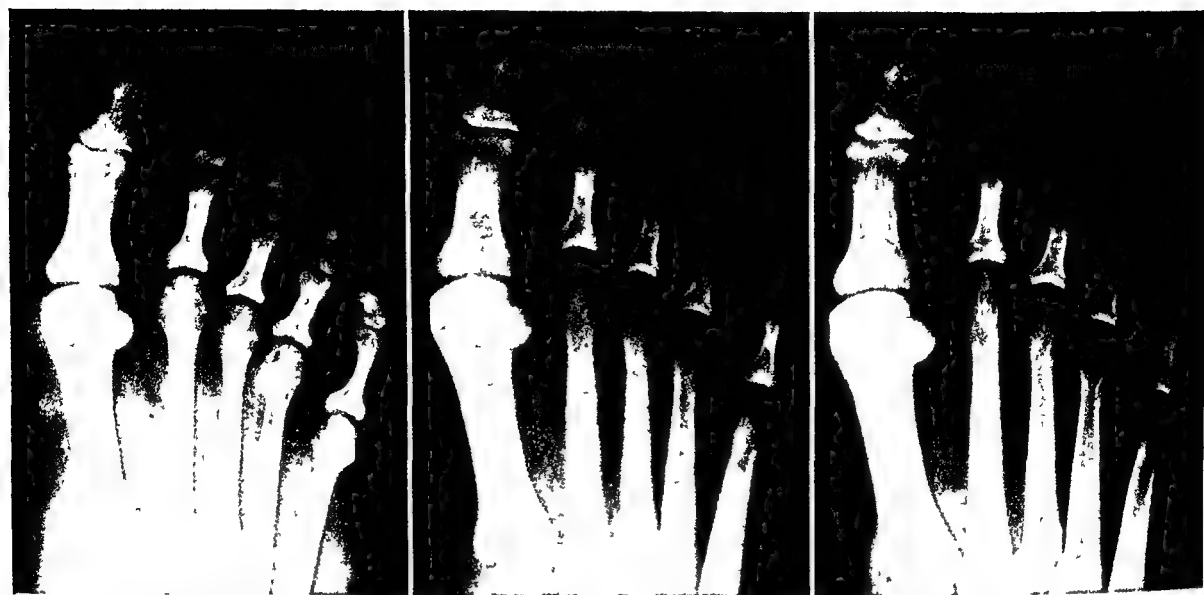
PRE-OPERATIVE ROENTGEN EXAMINATION—HELOVA DURUM, FIFTH TOE. Pre- and post-operative radiographs (immediate and thirty months later). (Courtesy of Dr Lester A. Walsh)
